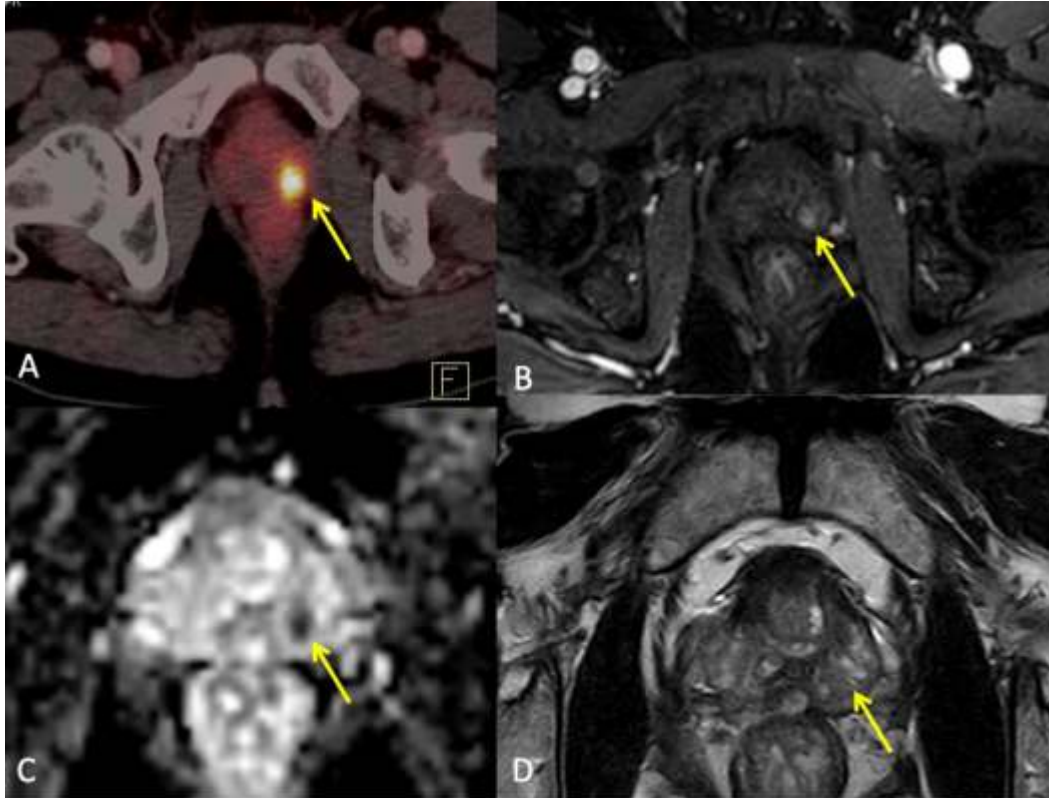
(A-D): Case 2. This elderly male had a small nodule detected on transrectal ultrasound with mild elevation of PSA 3.5ng/dl and came for simultaneous PSMA-PET/CT and mp-MRI. PSMA-PET/CT shows focal uptake in left peripheral zone (arrow in A). Dynamic perfusion study shows a focus of hyperperfusion in the early arterial image (arrow in B) with low ADC values on the diffusion study (arrow in C). The lesion is not well appreciated on the T2W image due to its small size.
